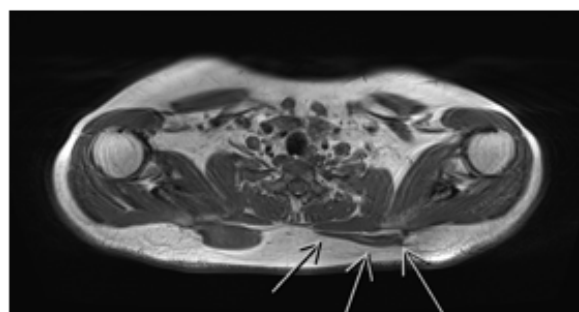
Axial MRI of the cervical and upper thoracic region demonstrating marked atrophy of the left trapezius muscle (white arrows) with increased signal intensity and volume loss with fatty infiltration, consistent with denervation changes following spinal accessory nerve neurapraxia.
